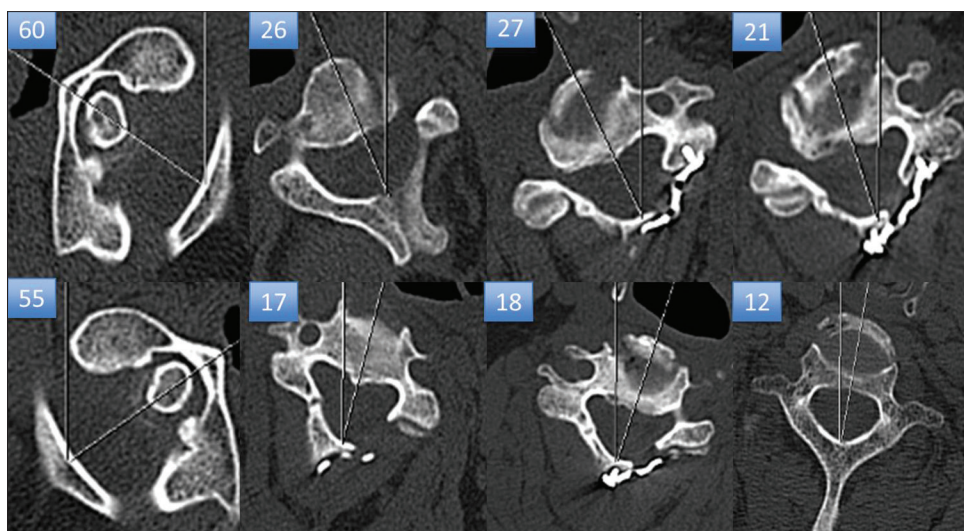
Postoperative axial computed tomography sections showing axial range of motion to the right and the left
